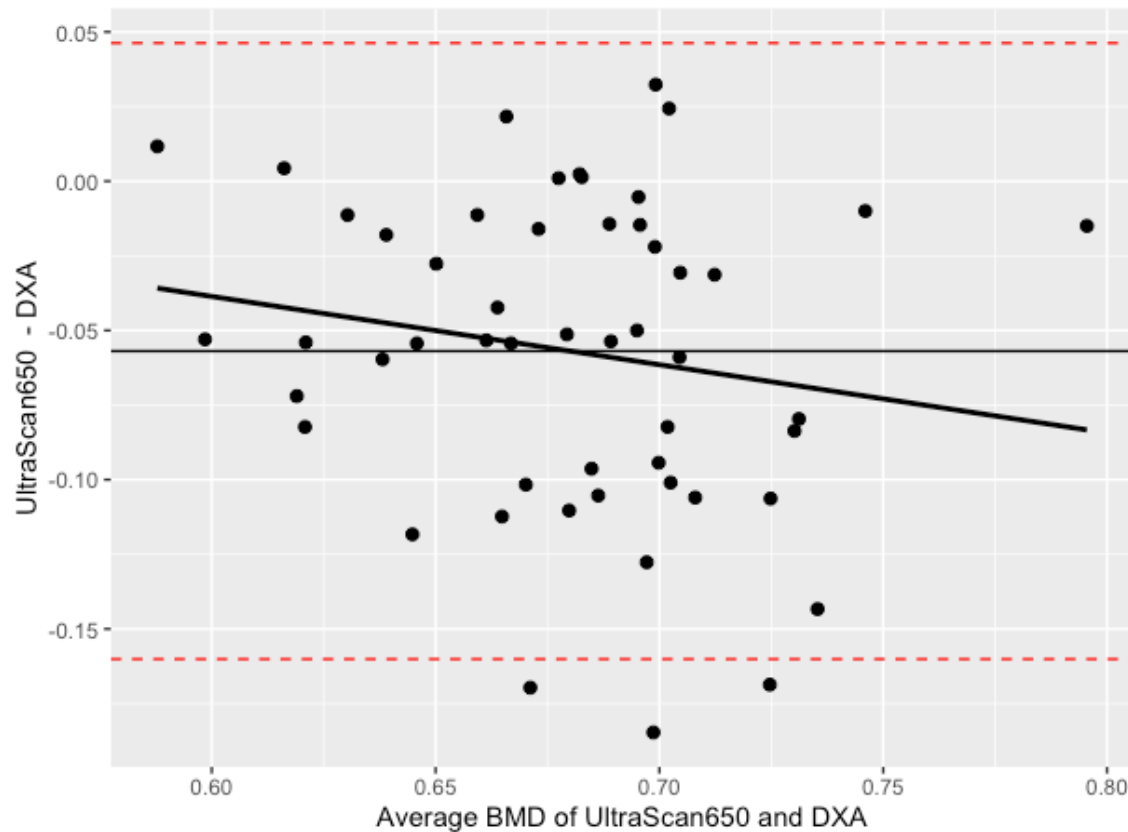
Bland-Altman plot with limits of agreement (LOA) relating bone mineral density (BMD) as measured by the UltraScan650™ and dual-energy X-ray absorptiometry (DXA). On the y-axis appears the difference between the UltraScan650™ and the DXA. On the x-axis appears the mean BMD for each participant as measured using the UltraScan650™ and the DXA. A trendline ($r = -0.170$) is present. The solid line represents how much the UltraScan650™ underestimates the DXA. The dotted lines represent the limits of agreement.
